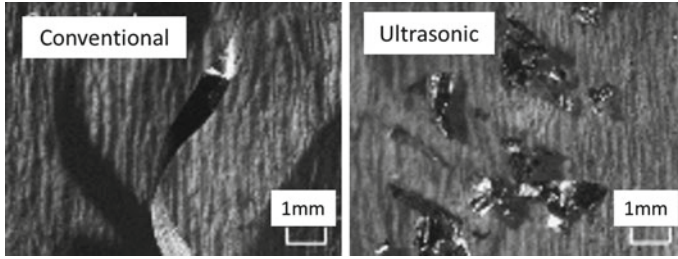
Comparison between chips generated in conventional and ultrasonic drilling (reprinted from Chang and Bone [48] with permission. © Elsevier)
